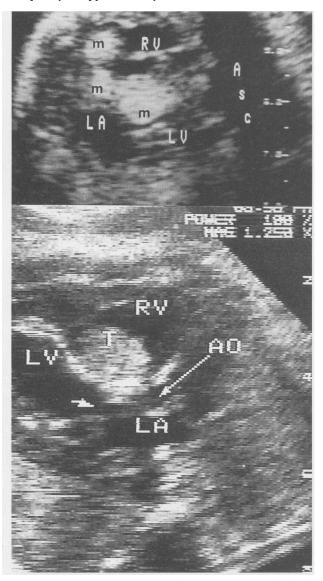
Two ultrasonograms taken from a fetus with a rhabdomyoma show a pattern consistent with a diagnosis of tuberous sclerosis. In the top frame, the masses (m) appear to be in the apex, the free wall of the right ventricle (RV), and protruding into the right atrium. The bottom frame shows a large tumor mass (T) within the ventricular septum and narrowing the left ventricular (LV) outflow tract. Note the brightness of the endocardium of the left ventricle, indicating endocardial fibrosis. The mass encroaches on the left ventricular outflow tract situated between the left ventricle and aorta (Ao). This fetus was found to have endocardial fibroelastosis as a consequence of the left ventricular outflow tract obstruction at birth (from Schmidt and Silverman<sup>48</sup>). LA = left atrium, LV = left ventricle, RV = right ventricle
